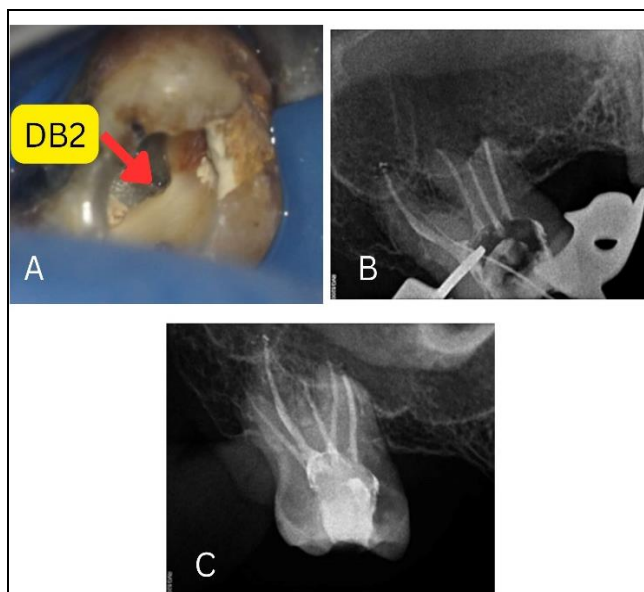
A. Location of DB2 canal, B. Working Length Radiograph of Newly Detected Canal (DB2) C. Final Obturation Radiograph
